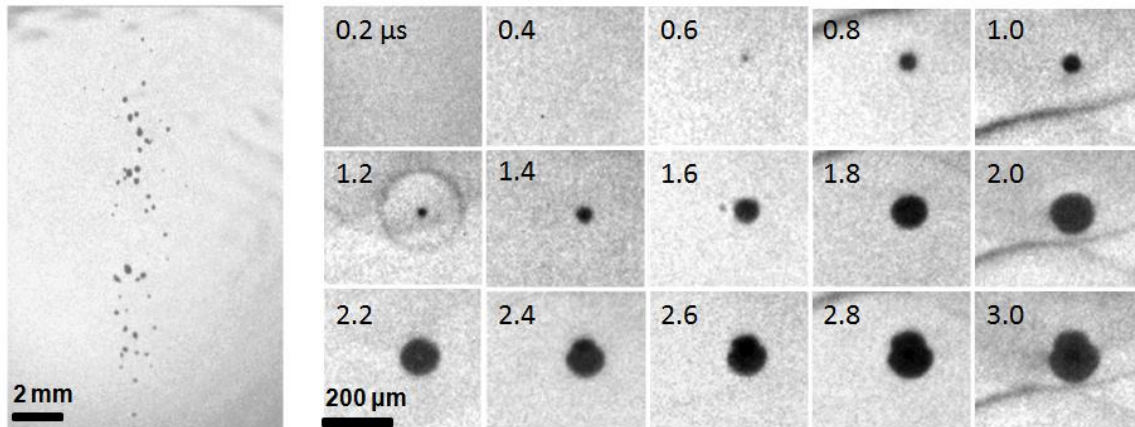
Single bubbles generated at the focus of a histotripsy transducer (top) and temporal behavior of an individual bubble during the first three cycles of a pulse (bottom). Ultrasound propagation was from left to right. Bubbles appeared in the initial cycles of the pulse, and underwent inertial collapse (an emitted shockwave is visible at $t = 1.2 \mu\text{s}$). However, bubbles did not continue to collapse during the later cycles, but instead deformed. Note, there is some small difference in the appearance and position of the shocks (dark lines) at $t = 1.0, 2.0,$ and $3.0 \mu\text{s}$ due to transducer ring up and camera spatial jitter.
